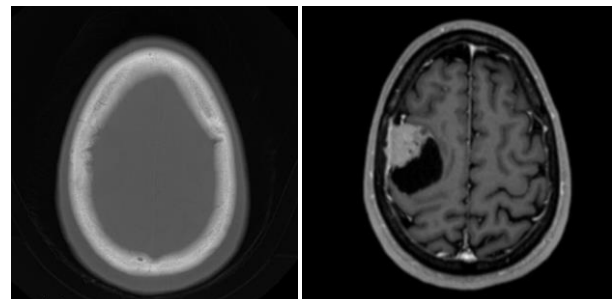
Bone invasion seen on CT scan and MRI slices.
